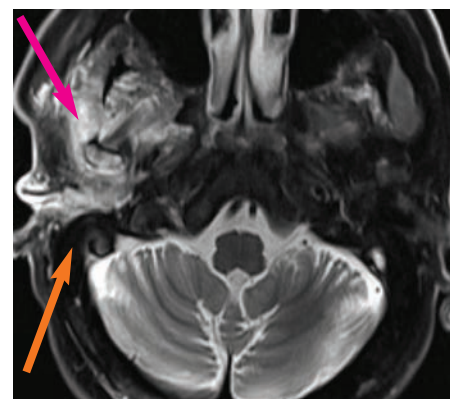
MRI T2W image (axial and coronal): Appearances are similar to CT in keeping with malignant otitis externa (orange arrows mark oedematous soft tissue in the middle and external ear cavities), most likely inflammatory in aetiology, with possible involvement of the mandibular condyle (marked by pink arrow) in keeping with osteomyelitis.
